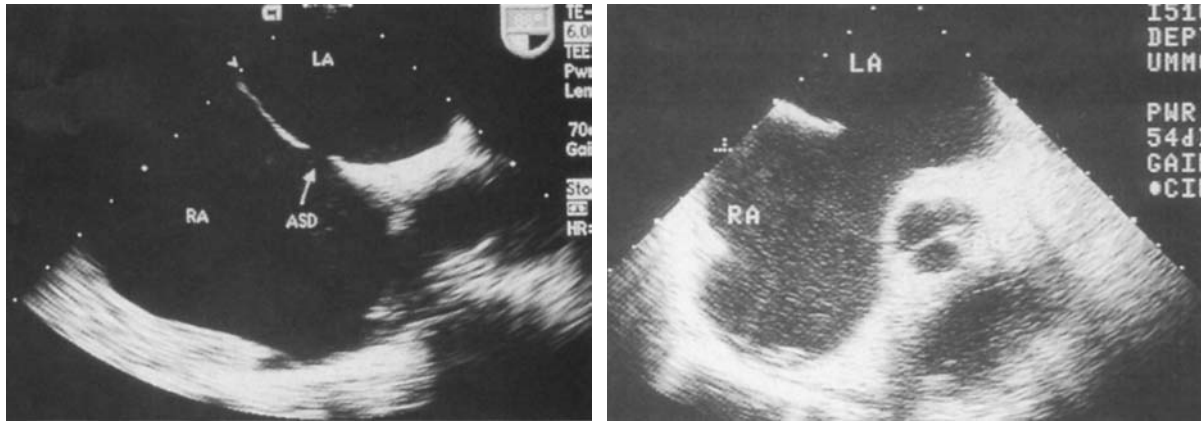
Transesophageal echocardiograms in two patients with atrial septal defects. In each case there is a distinct loss of tissue in the atrial septum, allowing direct communication between the left atrium and right atrium. (From Braunwald, E., *Heart Disease. A Textbook of Cardiovascular Medicine*, sixth edition, Philadelphia: W. B. Saunders, 197, 2001.)
